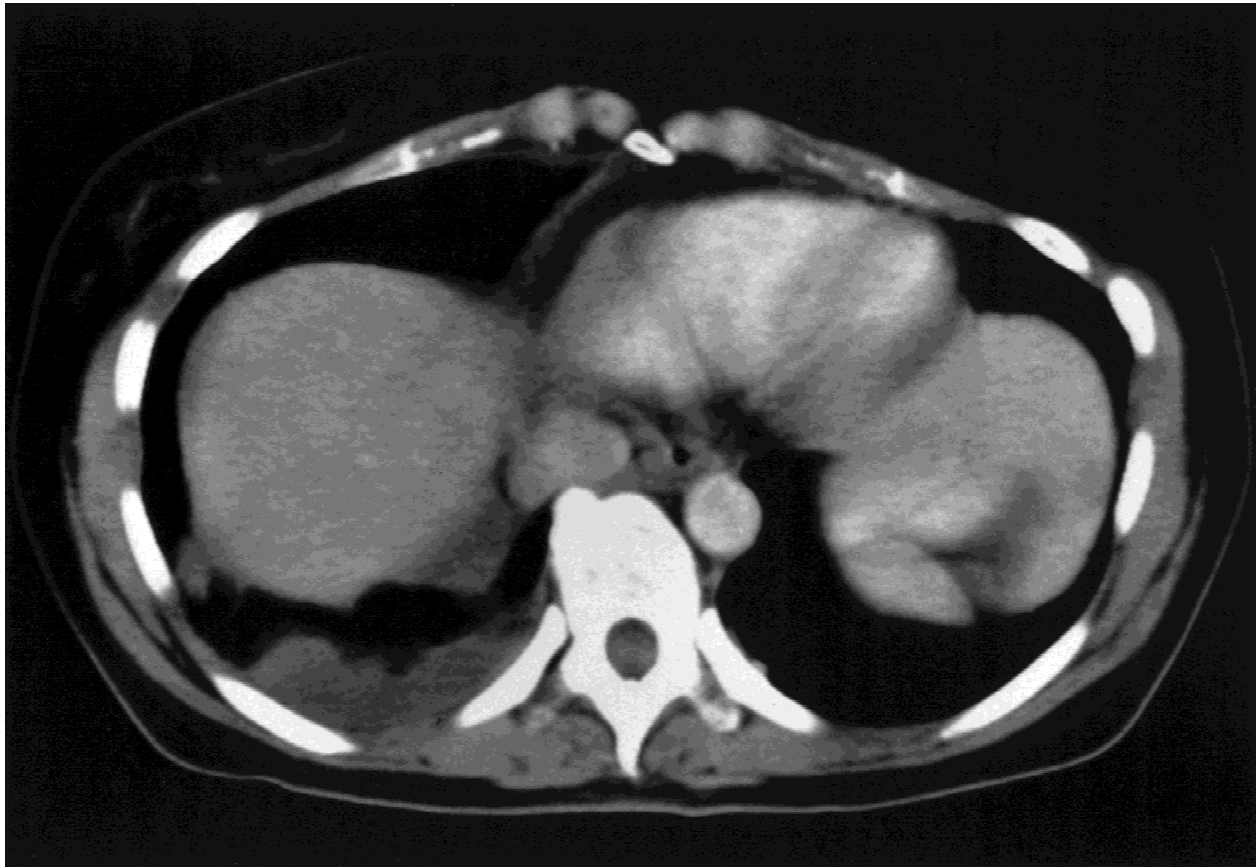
CT showing right pleural effusion consistent with globular accumulation of mucinous tumor.
